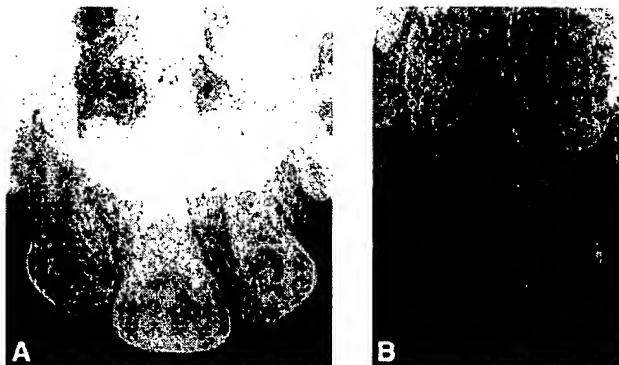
Radiographs of SMMCI in two unrelated individuals.
